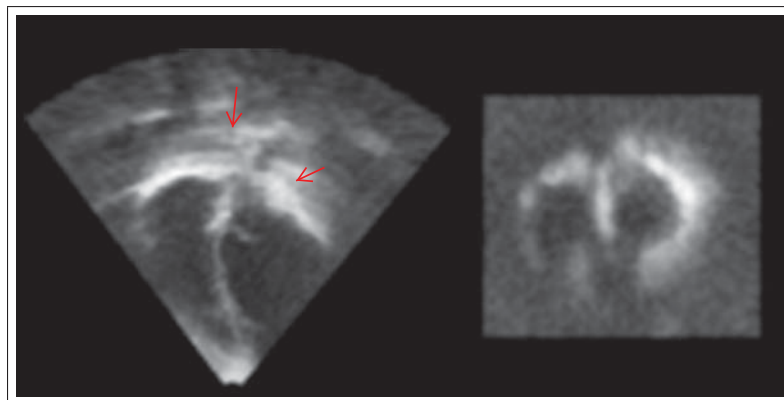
A cardiac ultrasound image from the long-axis view (left) and short-axis view (right). Red arrows point to shadowing artefacts. Ultrasound image from Guy's and St Thomas' Hospital, London.
